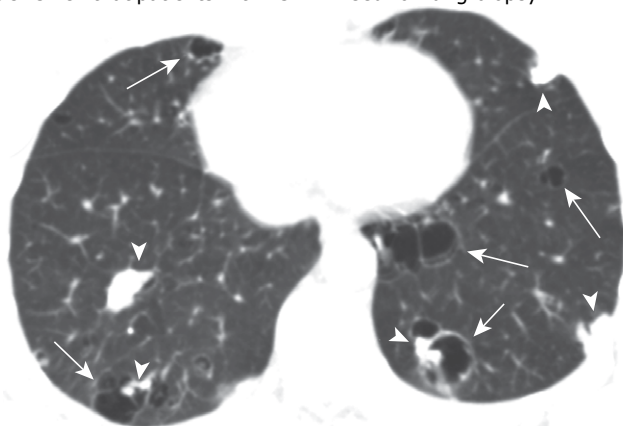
Axial CT scan of the chest with lung window settings at the level of the lung bases, showing multiple cysts (arrows) and calcified nodules (arrowheads). Note that some of the calcifications are within the cystic lesions.
